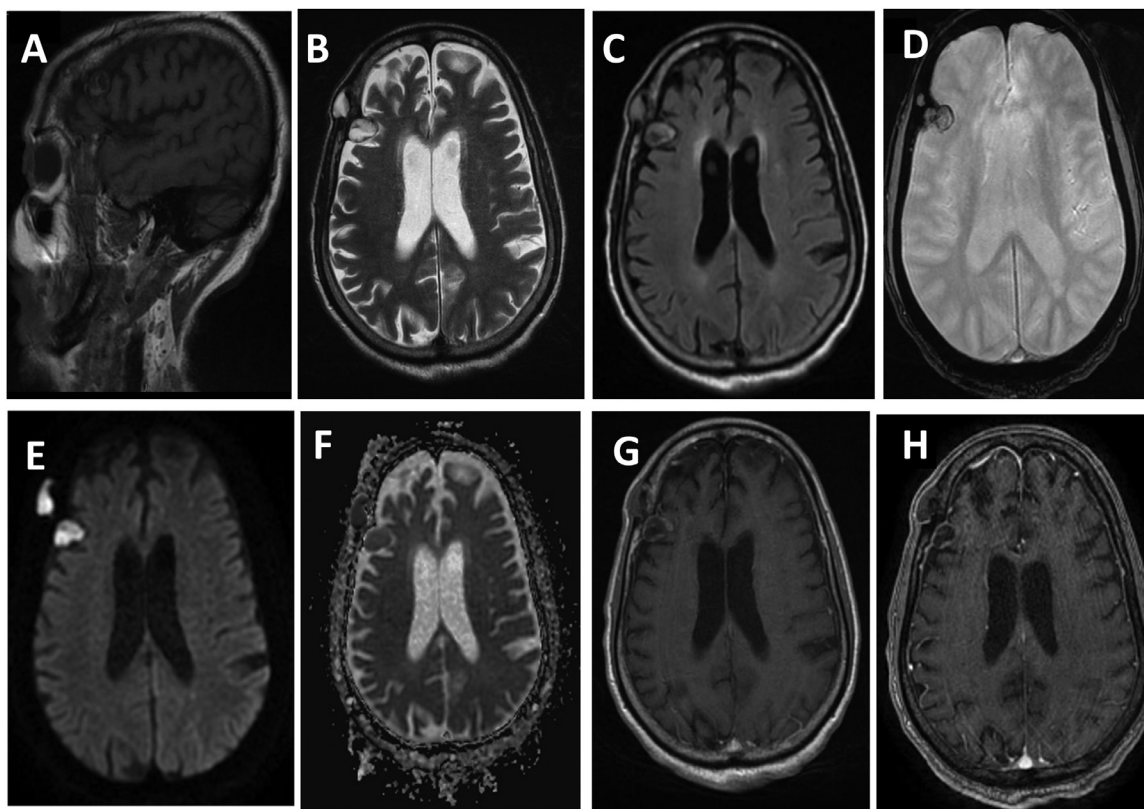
Cerebral MRI on sagittal and axial images showing 2 adjacent well-demarcated extra-axial lytic lesions in the right frontal bone with the erosion of the inner table, appearing as hyperintense on T1 WI (A), hyperintense T2 WI (B), inhomogeneous hyperintense on FLAIR sequence (C). Additionally, they exhibit a blooming artifact on the T2* sequence, indicating the presence of calcification (D). Moreover, the lesions appear hyperintense on diffusion-weighted imaging (DWI) and show restriction of Apparent Diffusion Coefficient (E-F). Furthermore, there is no enhancement observed after Gadolinium administration (G-H).
